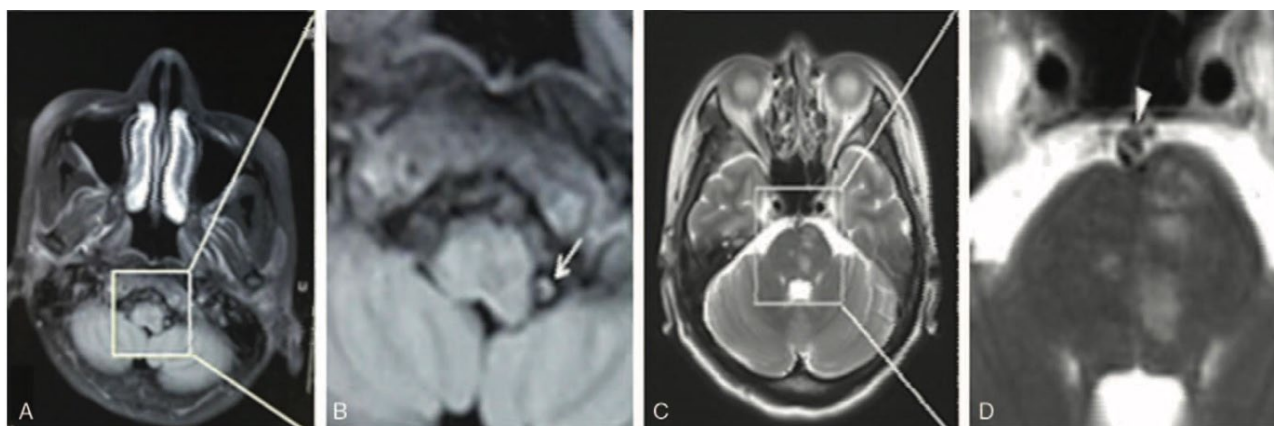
A) T1-Weighted MRI section showed a suspicious hyperintense mural hematoma [17]; B) A magnified image of a showing the mural hematoma; C) The following T2-weighted MRI section indicates an ischaemic stroke in the Pons with a double-lumen sign in the basilar artery; D) Magnified image of c depicting the “double-lumen” sign (arrowhead) [17].
